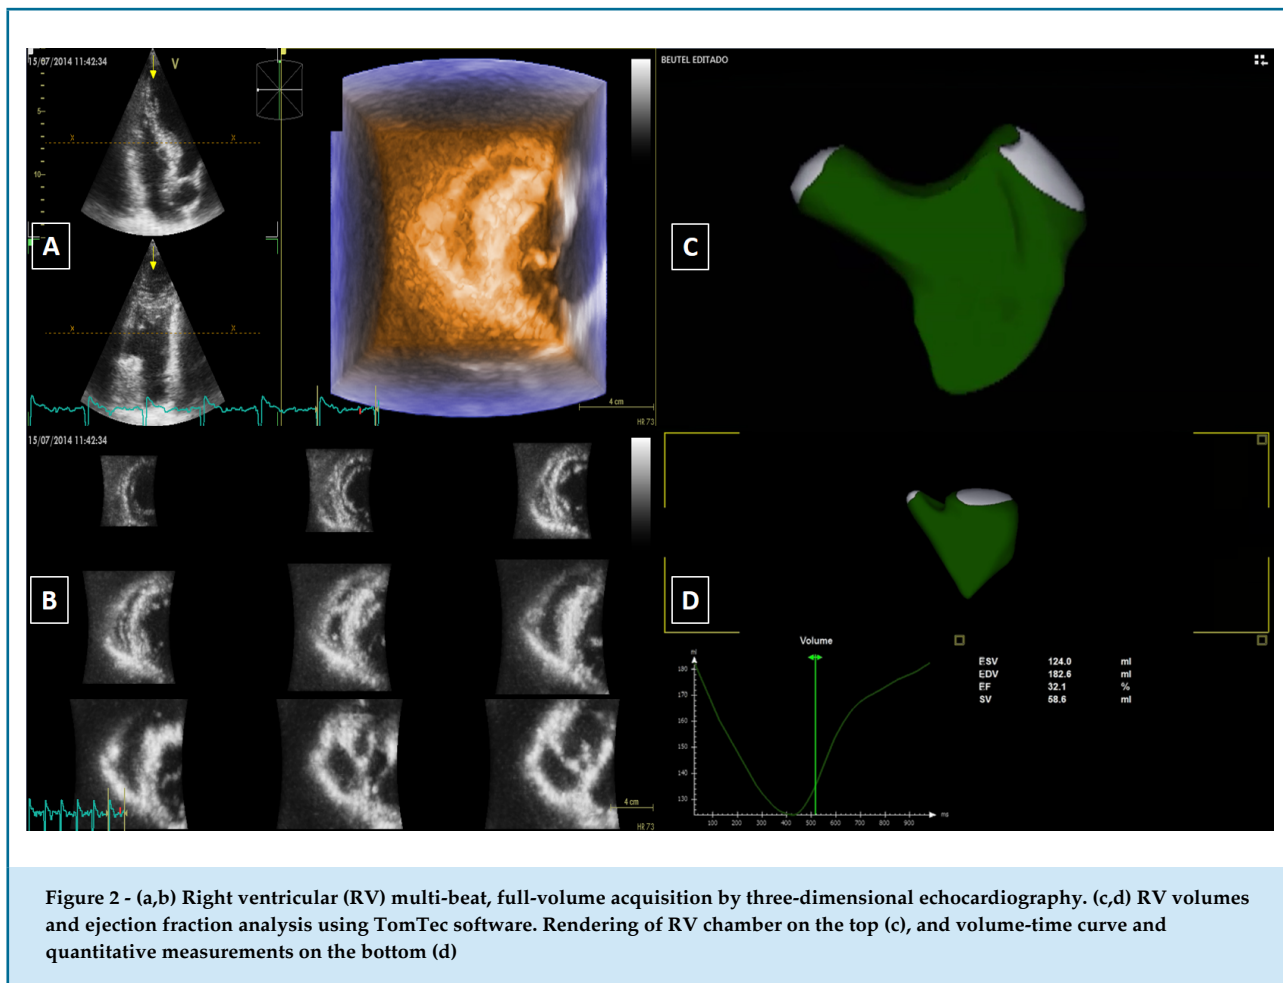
(a,b) Right ventricular (RV) multi-beat, full-volume acquisition by three-dimensional echocardiography. (c,d) RV volumes and ejection fraction analysis using TomTec software. Rendering of RV chamber on the top (c), and volume-time curve and quantitative measurements on the bottom (d)
